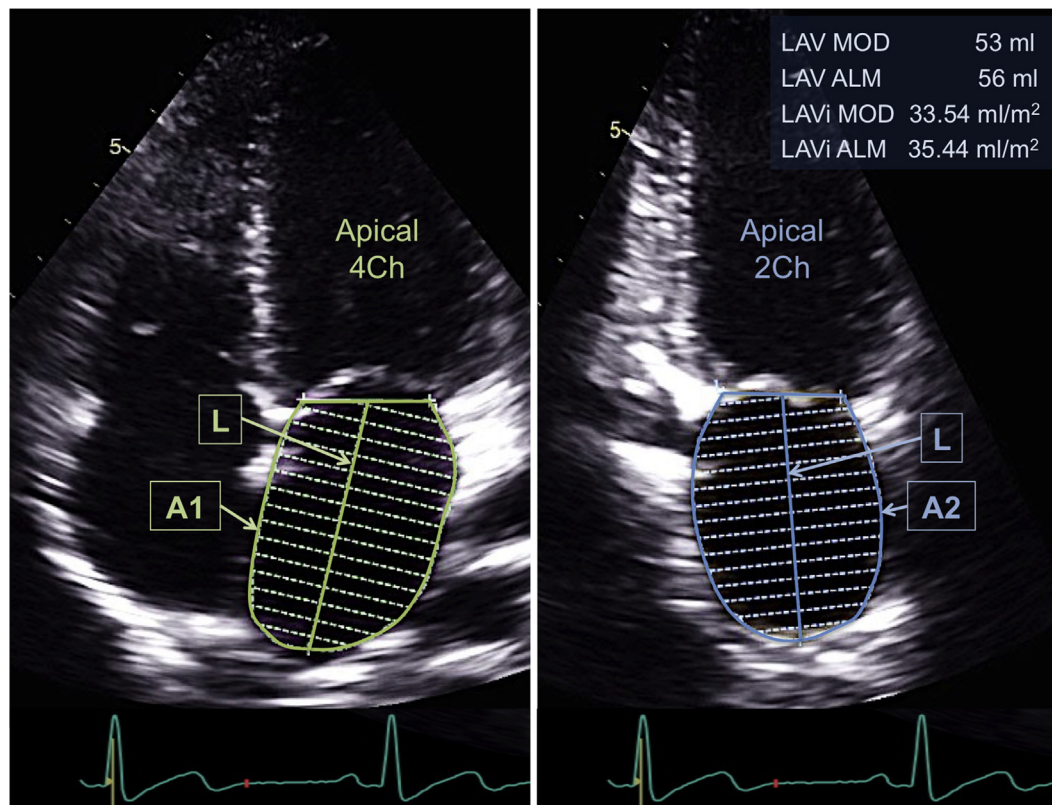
Two-dimensional echocardiographic assessment of LA maximal volume by MOD and ALM LA endocardium is traced in apical four-chamber and two-chamber views on the frame just prior to mitral valve opening, excluding the area under the mitral valve annulus and the inlet of the pulmonary veins. Then using the same endocardial tracings, LA volume was calculated using two currently recommended methods: (1) MOD, applying the following equation: $\pi/4(h) \sum (D1)(D2)$, where h is the height of the disks and $D1$ and $D2$ are orthogonal minor and major transverse axes of each disk. (2) ALM, applying the following equation: $8/3\pi \cdot [(A1 \cdot A2)/L]$, where $A1$ and $A2$ are the LA areas measured in the apical two- and four-chamber views and L is the shortest of the two long axes. According to the 2015 ASE/EACVI recommendations, the LA volume index (body surface area = 1.58 m^2) should be classified as normal, when measured by MOD, and mildly dilated, when measured by ALM. Applying the previous cutoff values from 2005, LA is classified as moderately dilated. 2Ch, two-chamber view; 4Ch, four-chamber view; LAV, LA volume; LAVi, LA volume indexed to body surface area.
